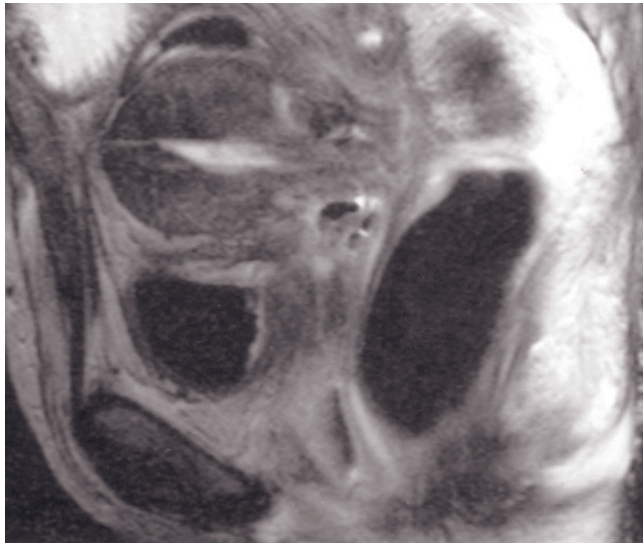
Bladder fistula. Sagittal (a), coronal (b), and transverse (c) T2-weighted single-shot echo-train spin-echo and sagittal T1-weighted gadolinium-enhanced fat-suppressed SGE (d) images in a patient after radiation therapy for ovarian cancer. The vaginal
